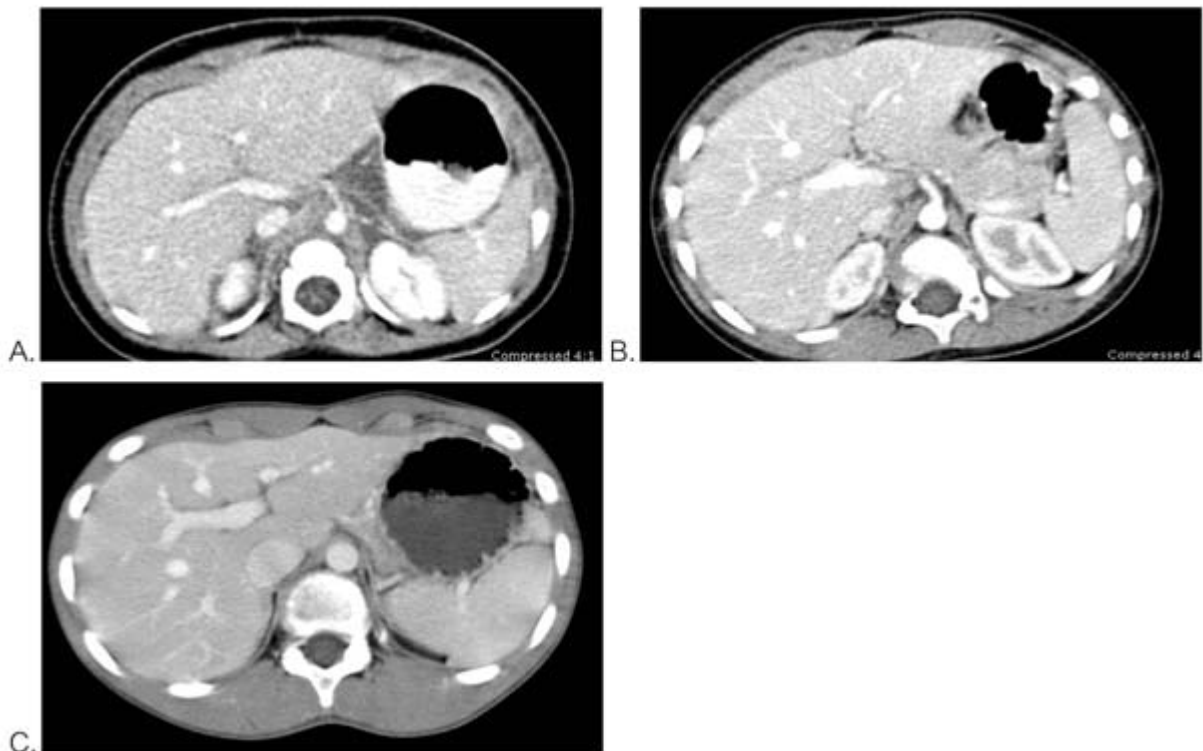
Whole abdomen CT
